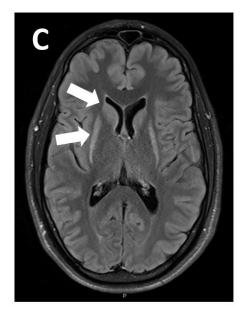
Magnetic resonance imaging of individuals with *MECR*-related neurologic disorder showing hyperintense T₂-weighted and FLAIR signals within the basal ganglia
